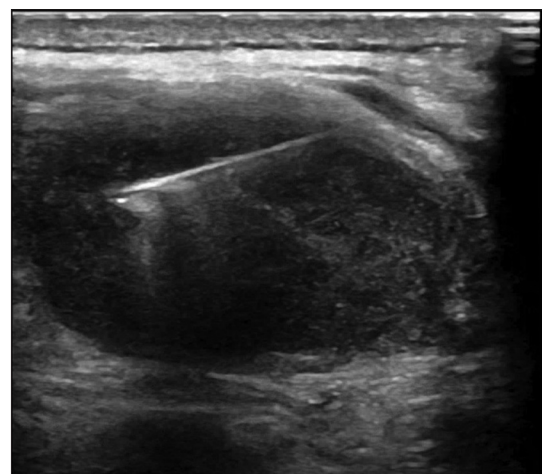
A 65-year-old male with metastatic squamous cell carcinoma. An ultrasound demonstrates a biopsy needle within a hypoechoic right paraspinal lesion
